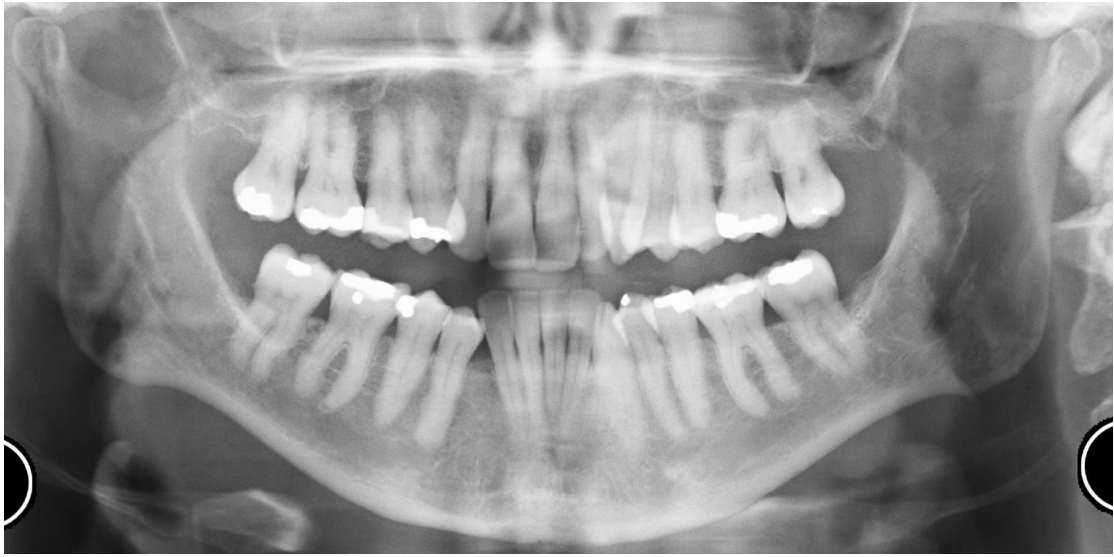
DPT radiograph showing absent third permanent molars
